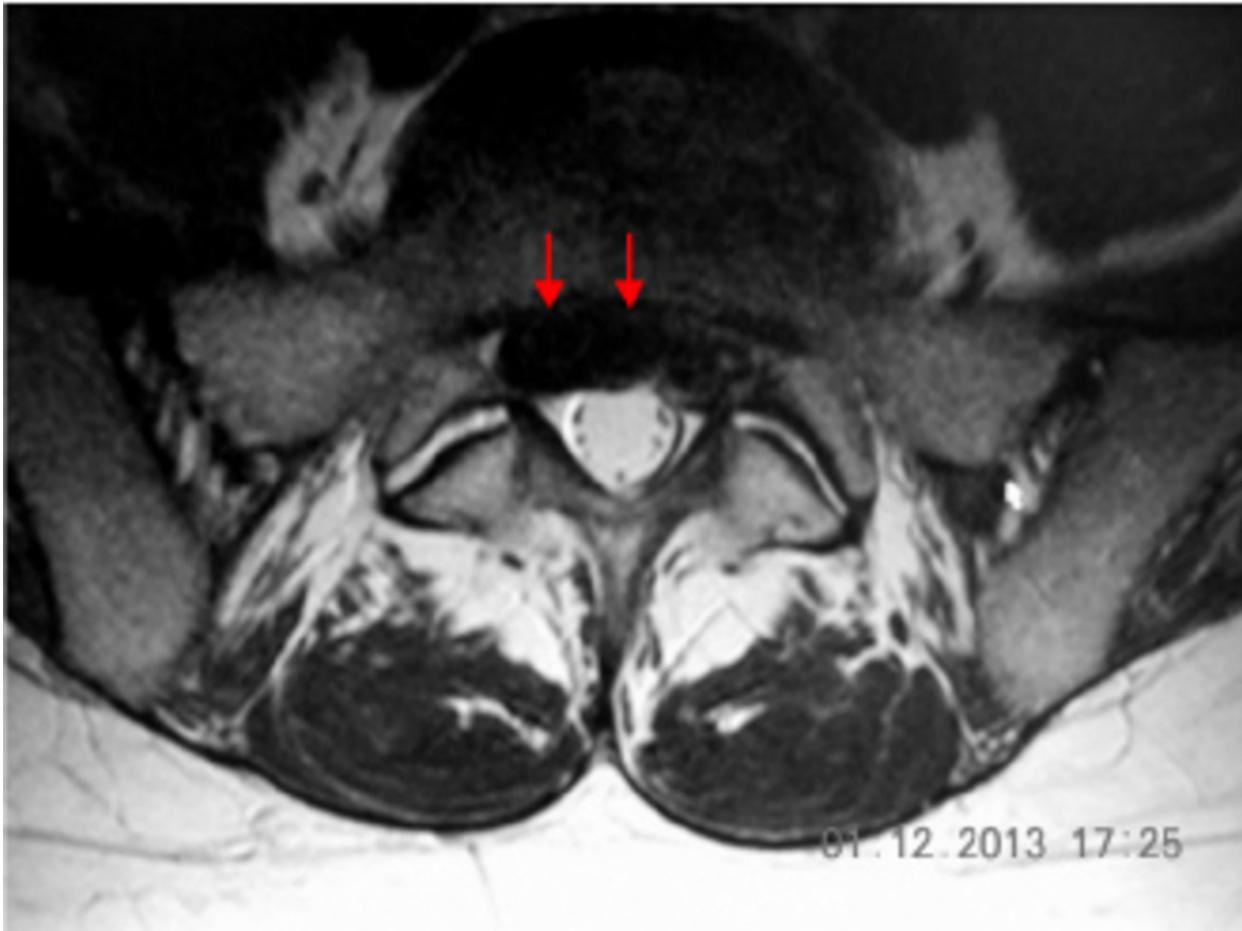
Axial T2 Weighted Lumbar Spine MRI. Central Disc Herniation Extending To Right Subarticular Zone
